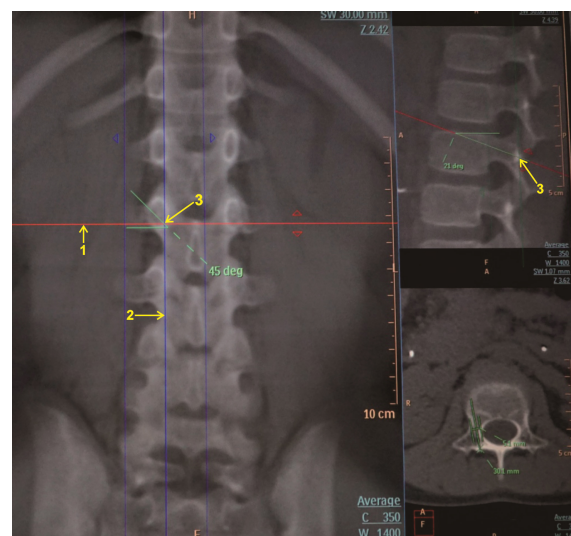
Determination of the starting point for cortical bone trajectory screw placement. Notes: 1, the red line was the horizontal axis, which can be used to calibrate the axial plane; 2, the blue line was the sagittal axis, which was used to adjust the sagittal plane; 3, the screw insertion point was located in the 5 o'clock orientation of the pedicle. The orientation markers on the CT workstation indicate anatomical directions: A, anterior; P, posterior; F, foot/inferior; H, head/superior.
